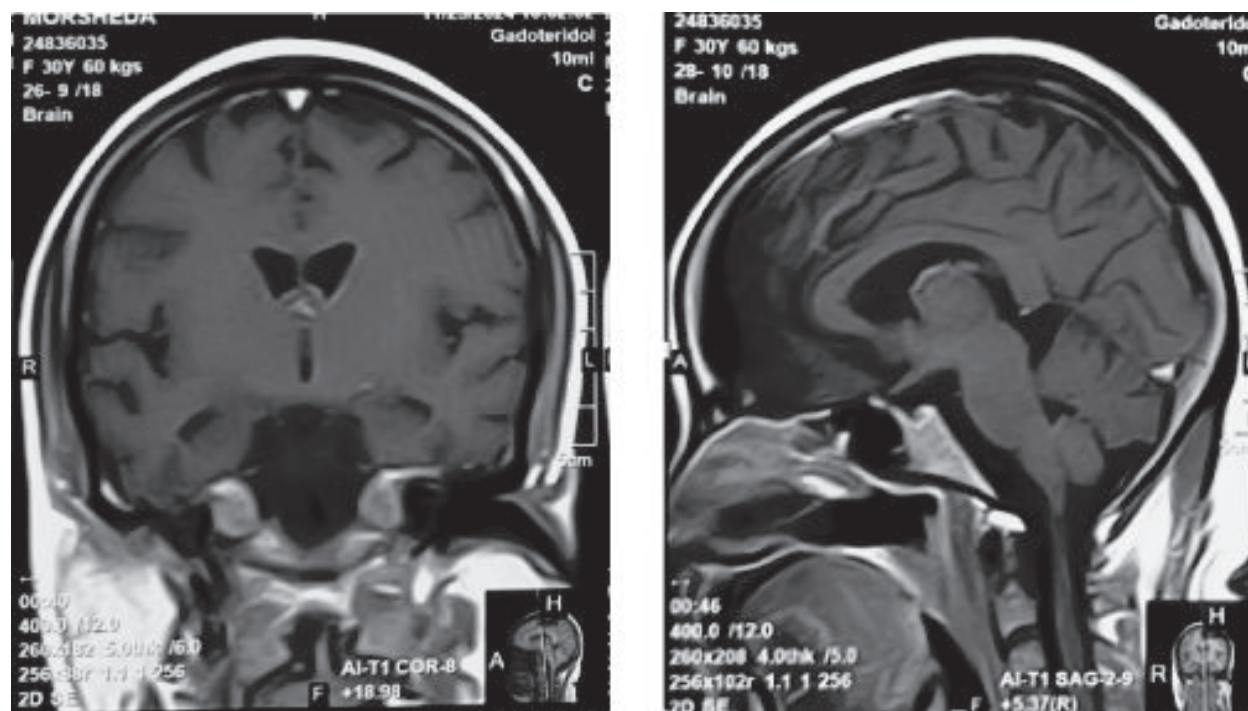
showing follow up MRI brain coronal and sagittal cut T1 contrast sequence showing near complete resolution of lesion after one month treatment with prednisolone.
